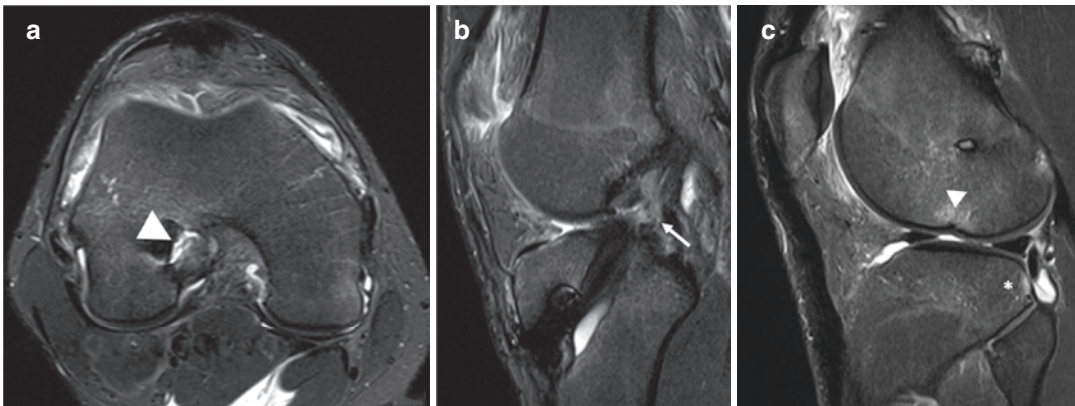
Complete ACL graft tear on MRI. Axial image (a) demonstrates a fluid filled full-thickness defect (arrowhead) of graft fibers adjacent to the femoral tunnel. Sagittal image (b) demonstrates redundancy of graft fibers, which
